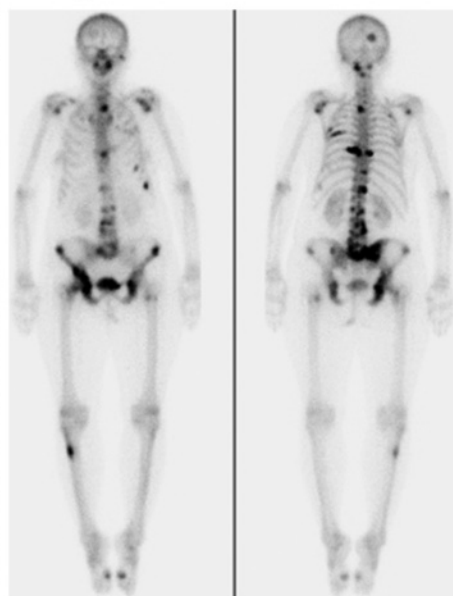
Metastatic disease as seen at conventional imaging. (a) Axial contrast material–enhanced T1-weighted MR image of the brain obtained in a patient with known primary lung cancer shows a ring-enhancing lesion with surrounding edema in the right occipital pole (arrow), a finding that is consistent with metastasis. (b) Abdominal CT scan obtained in a different patient shows multiple enhancing hepatic masses (arrows) and a right adrenal mass (arrowhead), findings that are consistent with metastatic disease. (c) Technetium-99m methylene diphosphonate nuclear bone scintigrams obtained in a third patient with lung cancer show multifocal areas of abnormal radiotracer uptake in the axial and appendicular skeleton, findings that are consistent with metastases.
